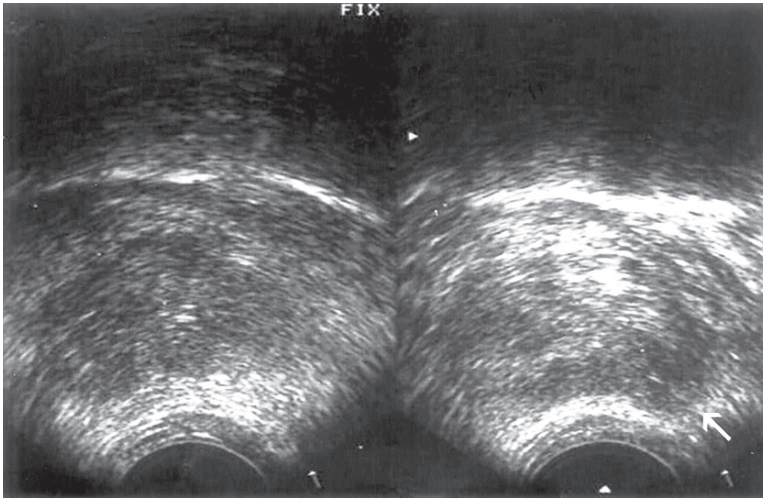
Different gray scale transrectal ultrasound findings suggestive of extracapsular extension of PC. A hypoechoic tumor in the peripheral zone with capsular bulging and obvious thinning and distortion of periprostatic fat (white arrow)
